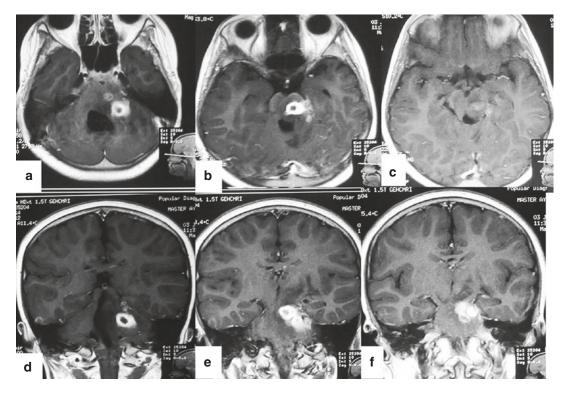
Contrast MRI of the brain at the age of 6 years (the patient developed ataxia and repeated fall); (a-c) axial images and (d-f) coronal images showing recurrent tuberculoma in brachium pontis and pons
